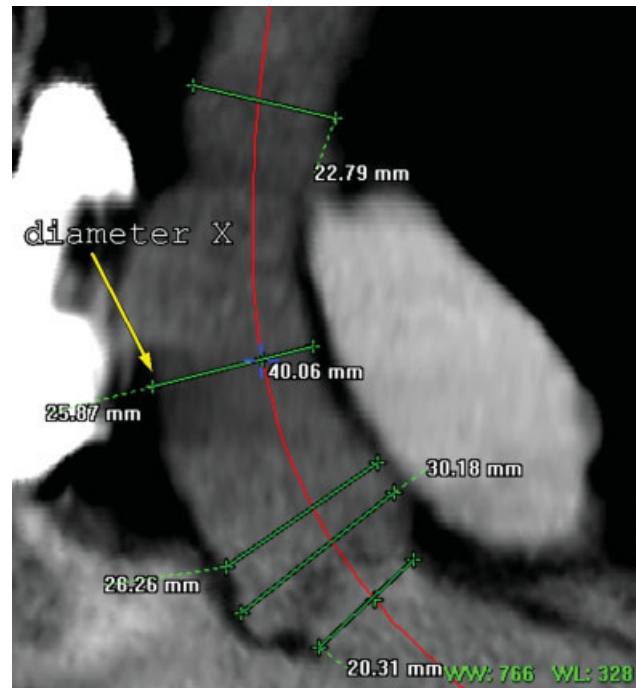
CTA measurements of the aortic annulus and ascending aorta.
